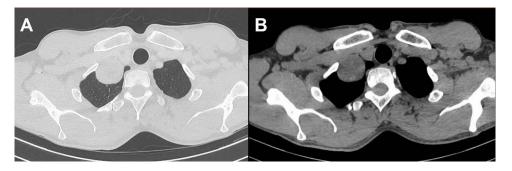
16-slice computed tomographic scan showed a mass image in the upper lobe of the right lung adjacent to the chest wall. The tubercle boundary was clear and the internal density was uneven. Careful examination showed that the mass had a pedicle. (A) Lung window; (B) Mediastinal window.
